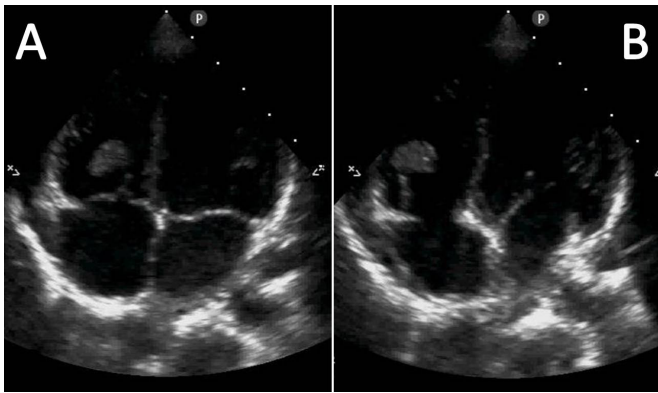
A and B, Apical 4-chamber view with the sector probe. Tumor attached to the right ventricle chordae in the subvalvular tricuspid valve apparatus.
